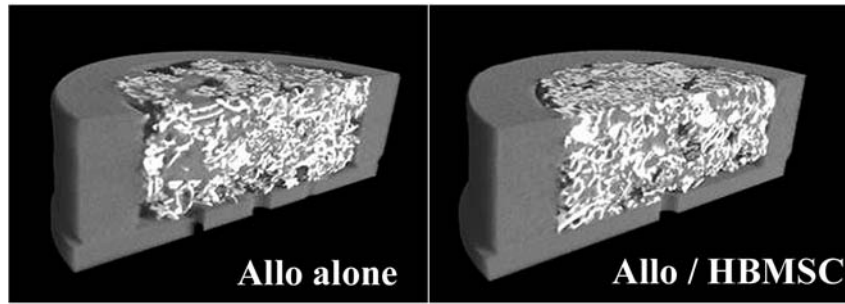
3D Micro CT images (Allograft). 3D reconstruction of Allograft & Allograft / HBMSC samples
